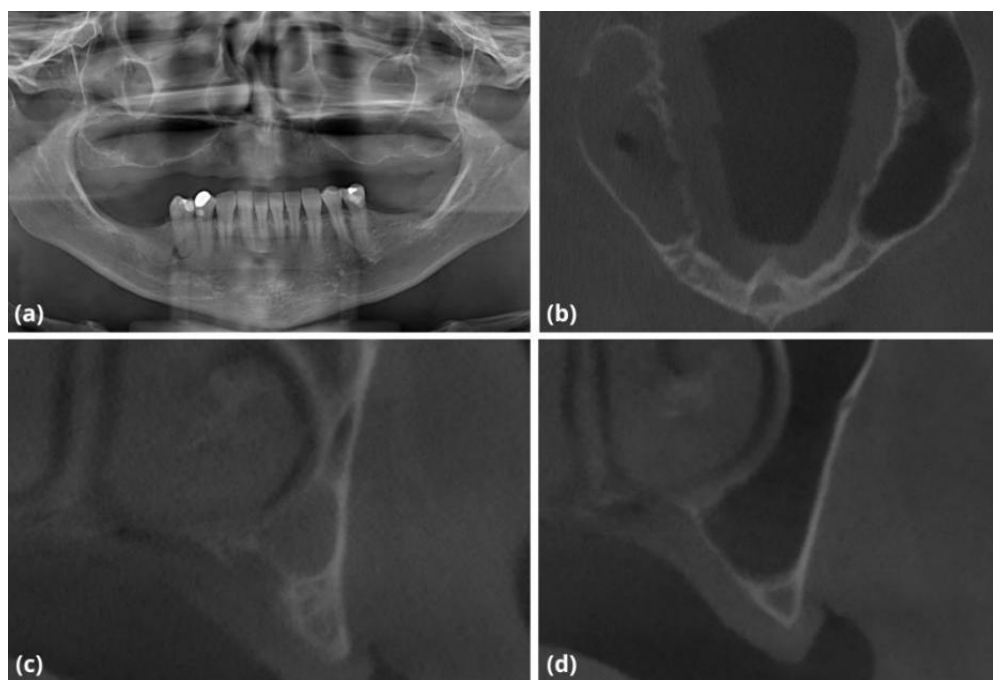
Radiographic findings from the initial situation. Panoramic radiograph (a). Axial and cross-section from the CBCT of maxilla (b-d).
